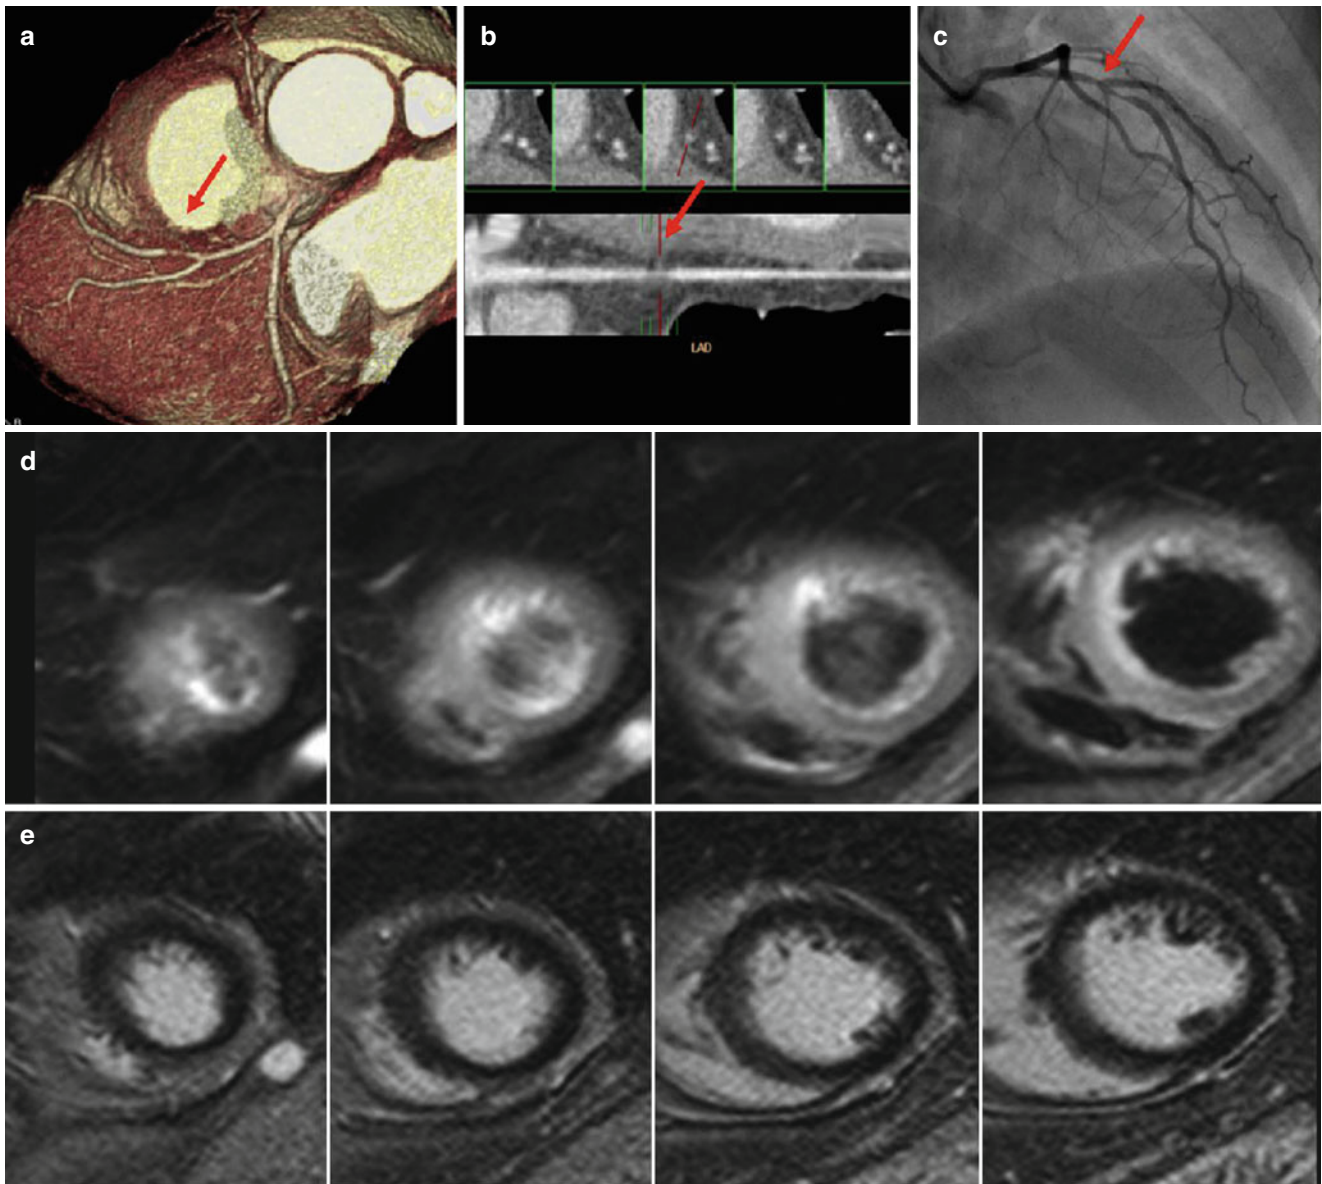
Aborted MI. Severe discrete stenosis (*arrow*) was noted at mid-LAD on coronary CT angiography (a, b) and conventional angiography (c). Occluded LAD was successfully reopened after
